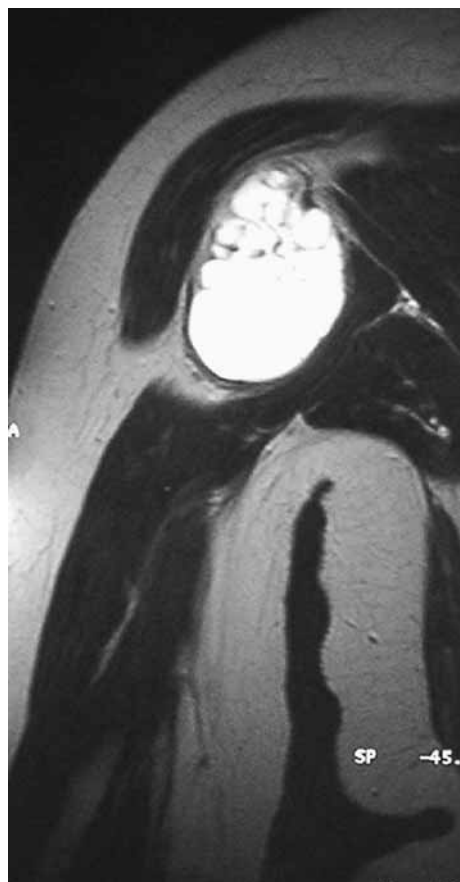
MRI aspect on frontal view
